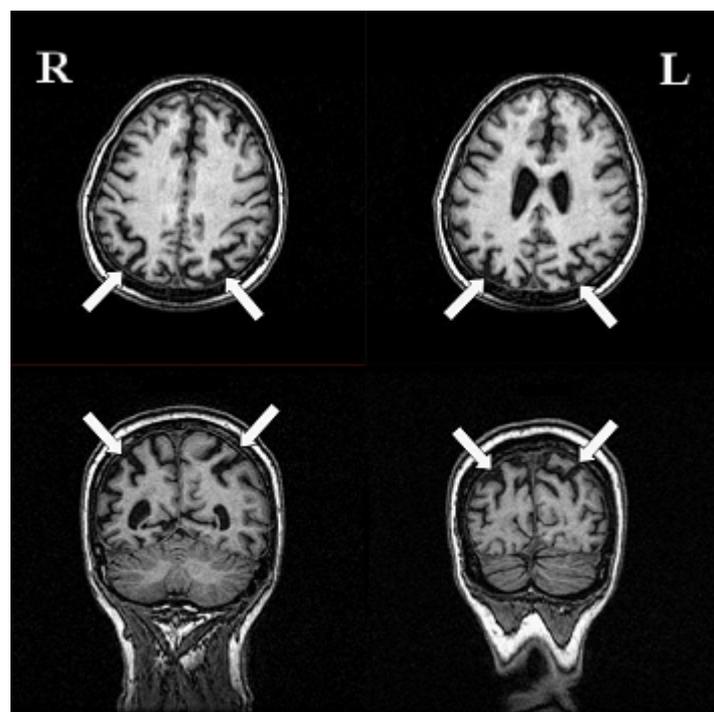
MRI - arrows indicate parietal damage, more pronounced in the left hemisphere.
